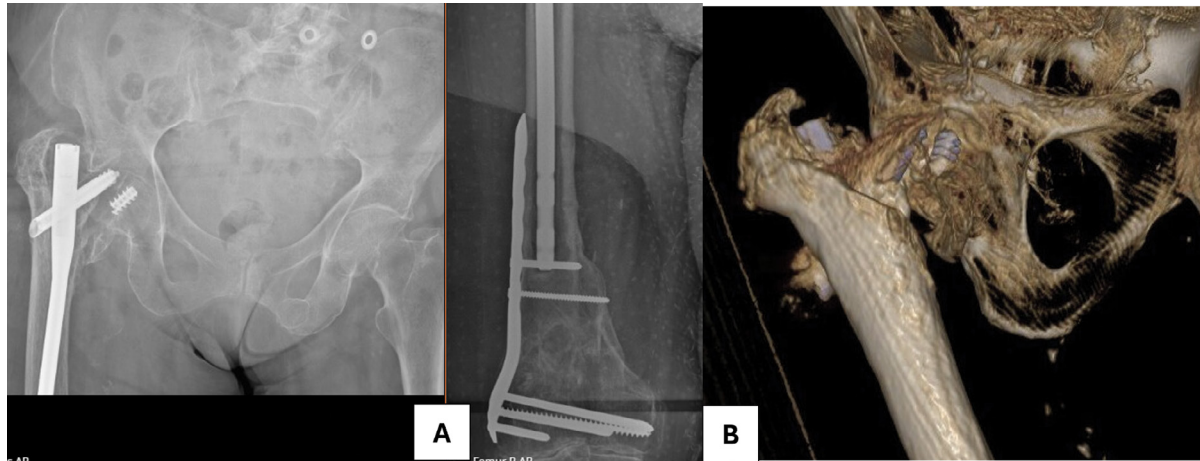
A) X-rays showing Broken lag screw of TFNA with non-union (AP of the pelvis with hips and AP of distal femur). B) CT scan confirming non-union with the broken screw seen eroding the acetabulum.
